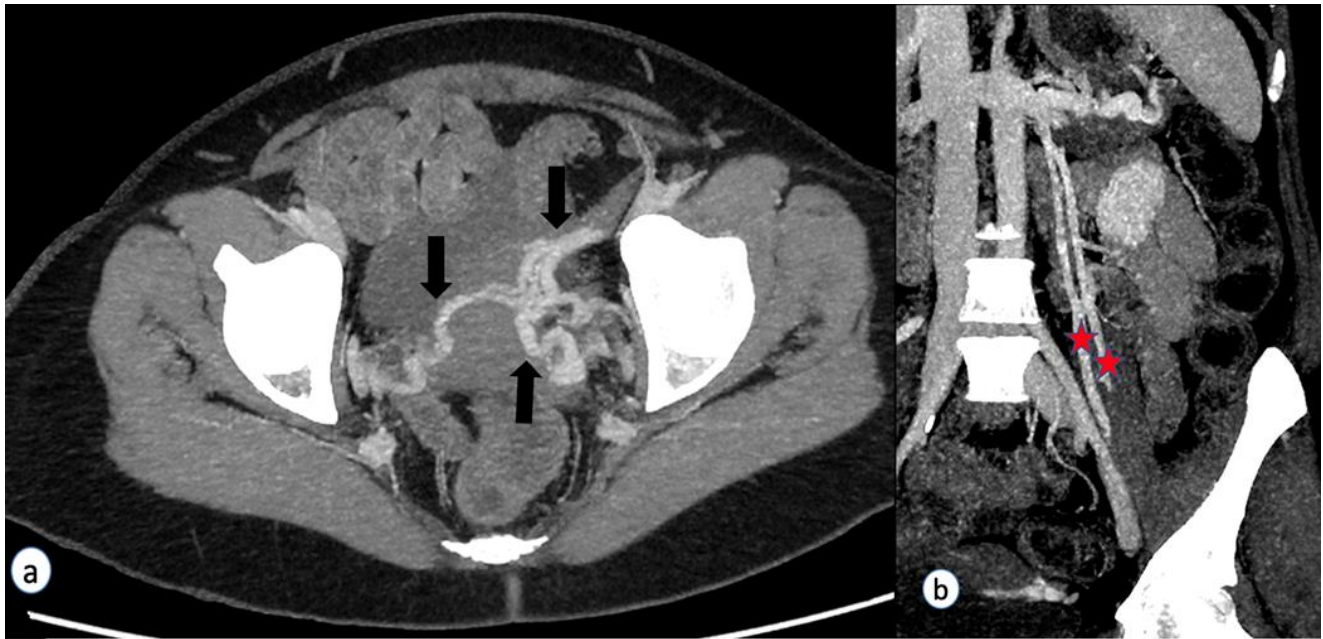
Maximum Intensity Projection (MIP) of contrasted CT Abdomen.
